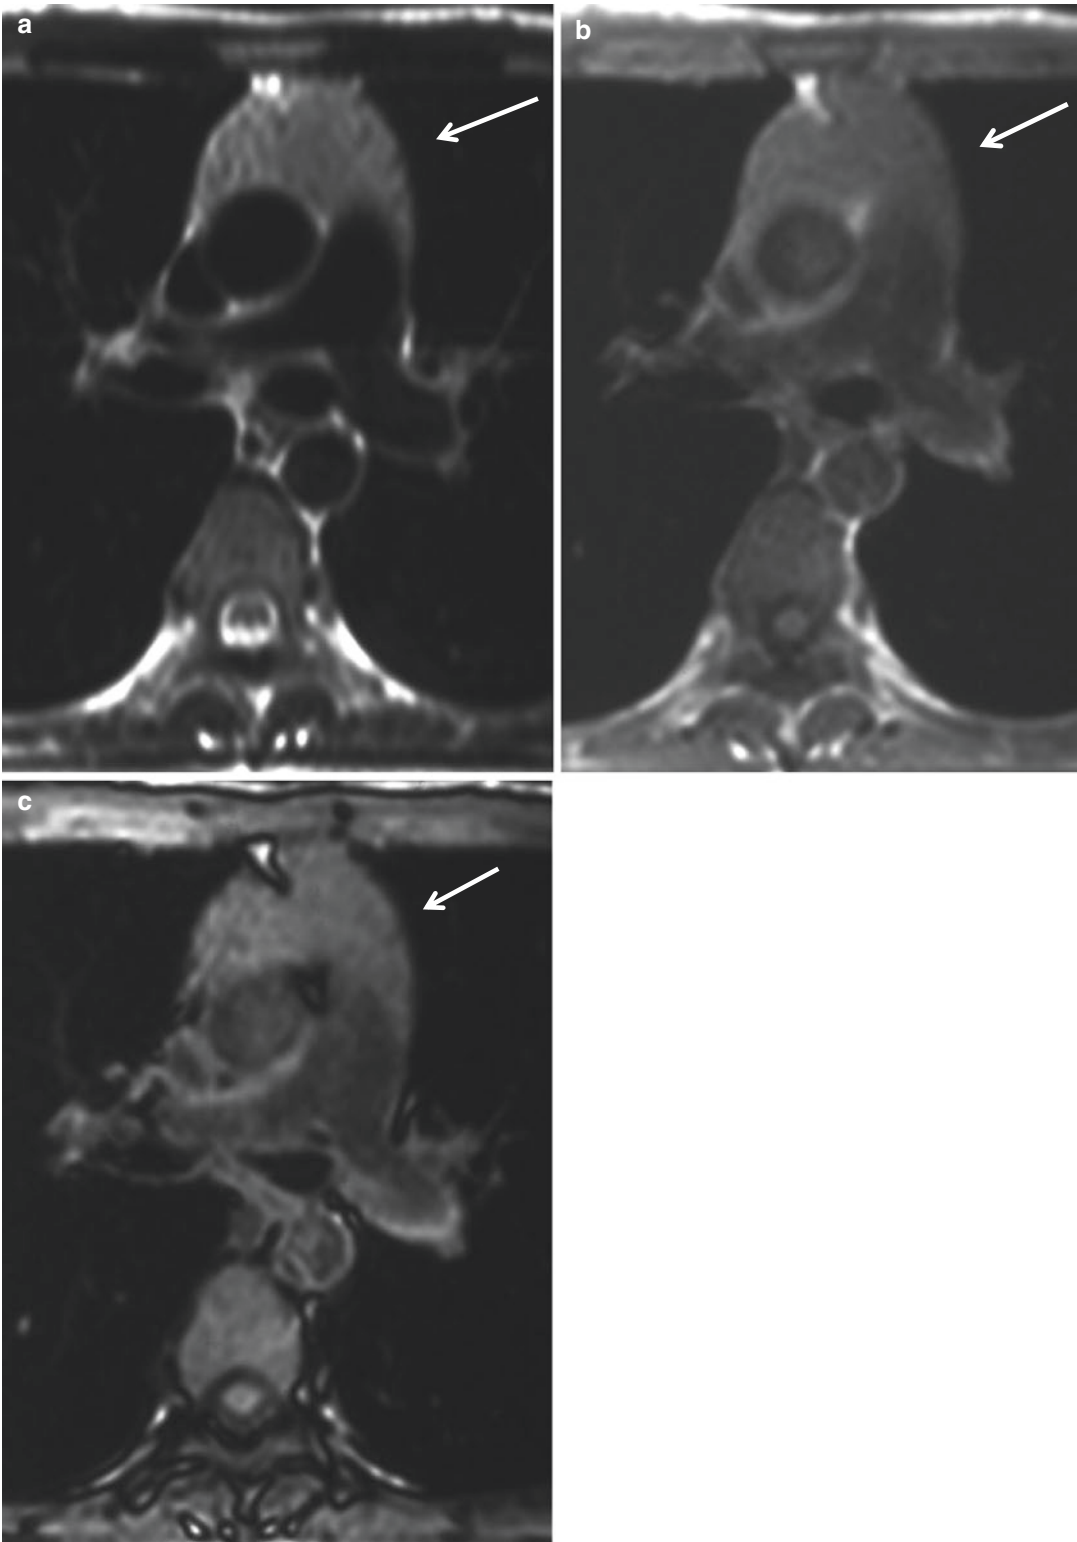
Noninvasive thymoma. T2-weighted (a) and in-phase (b) and opposed-phase (c) gradient-echo T1-weighted MR images. A lobulated mass lesion is
